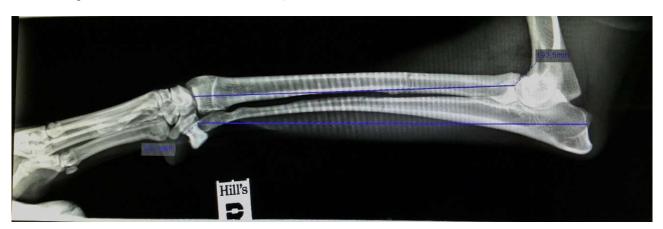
Measurement of ulna and radius in radiograph. Author: K. Ramanauskaite
